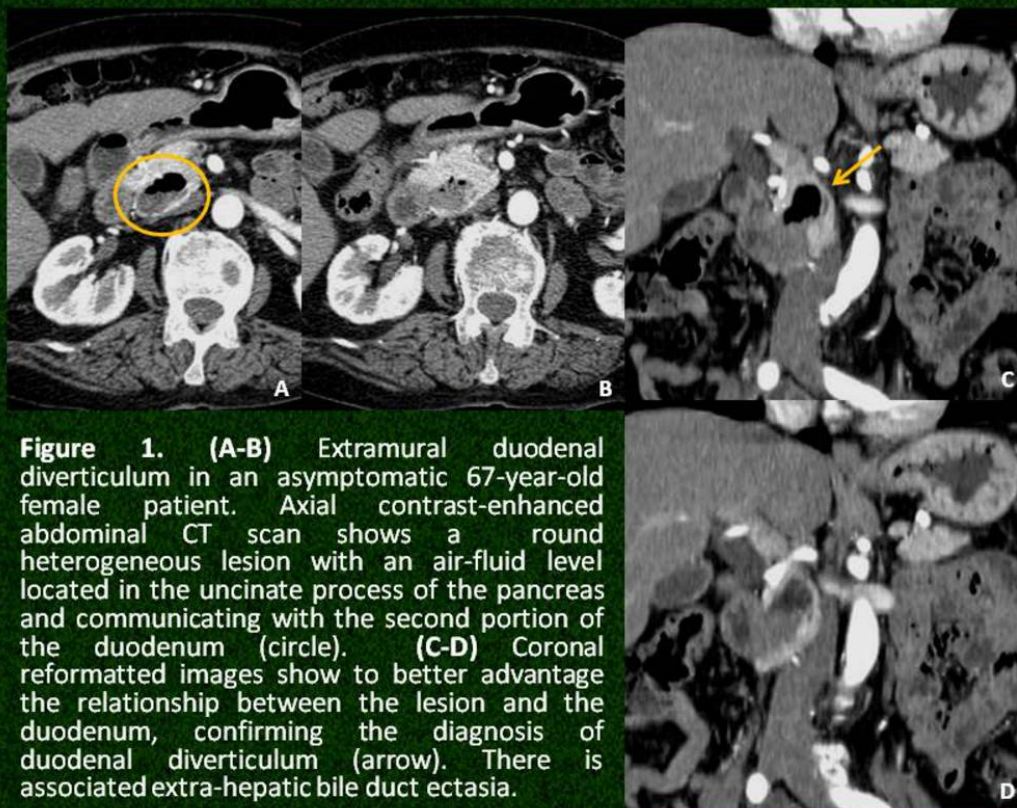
Extramural Diverticulum - CT
